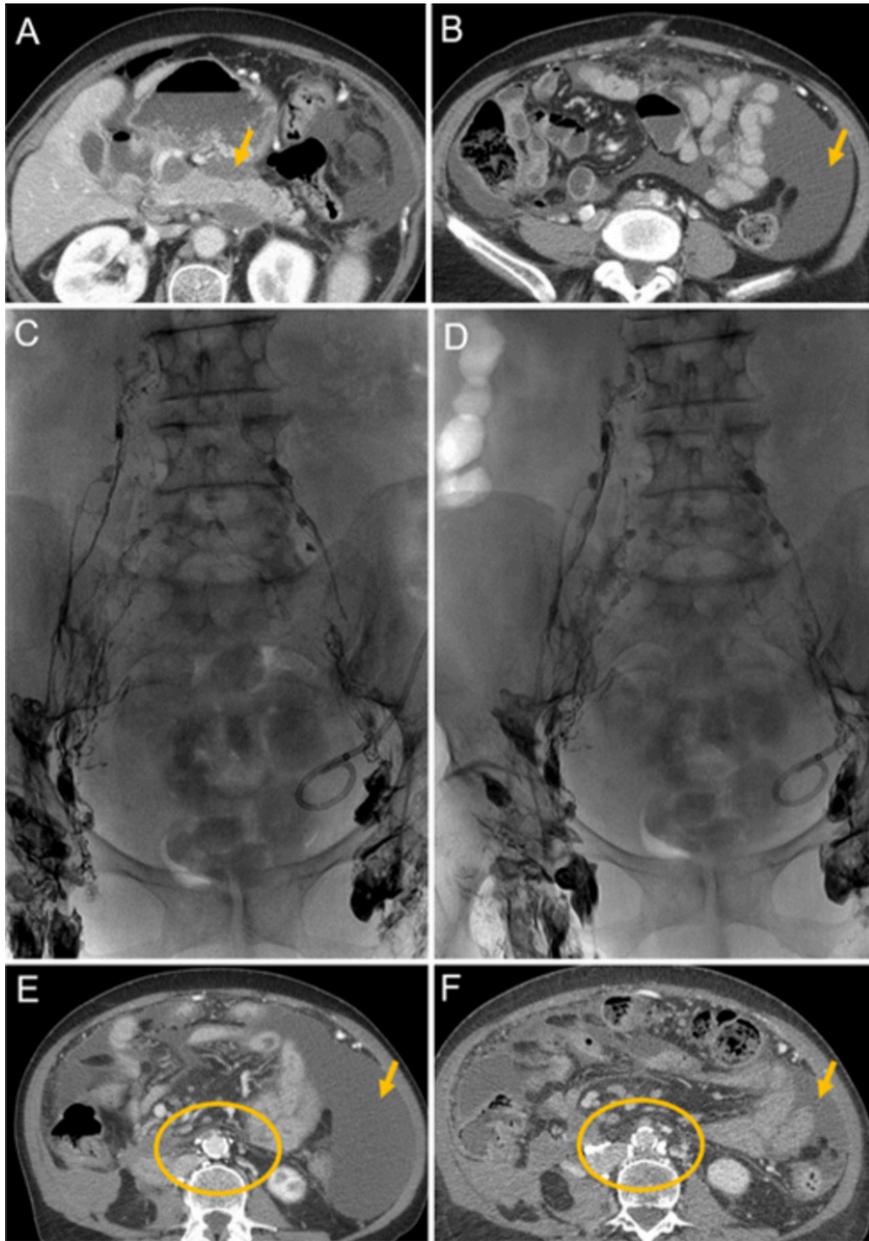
Chylous ascytes secondary to acute pancreatitis. (A,B) Axial CT images demonstrating peripancreatic walled-off necrosis with associated ascite (arrow). (C,D) After the failure of the conservative measures, LG was performed with lipiodol without evidence of chylos leakage. (E,F) Axial CT images after performing LG and control three weeks later. Note the remnants of lipiodol in the retroperitoneal ganglia (circumference) and the decrease in ascitic fluid (arrows).
